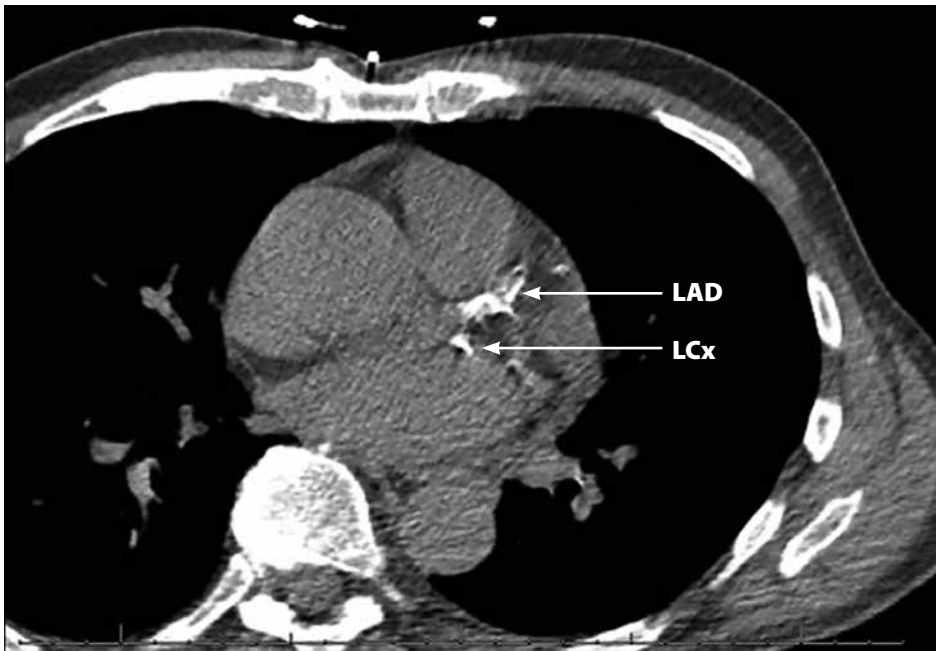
Sample coronary artery calcium scoring CT scan. A significant burden of calcified plaque can be seen in this patient with a high coronary artery calcium score, in both the left anterior descending (LAD) artery and the left circumflex (LCx) artery. The total calcium score was 944: left main coronary artery: 0, LAD artery: 643, LCx artery: 128, right coronary artery: 173.
